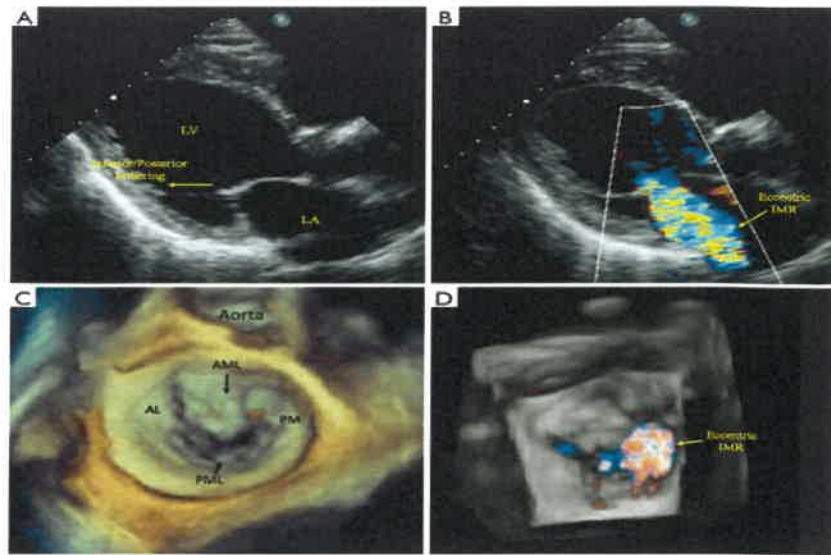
Asymmetric pattern of mitral valve tethering on two- and three-dimensional echocardiography. Asymmetric mitral valve leaflet tethering in the inferior/posterior direction (yellow arrow) results in posteriorly-directed eccentric ischemic mitral regurgitation (IMR) (A,B). En face (surgeon's view) of the mitral valve exemplifies the resultant regurgitant orifice, which is more medially located, and the eccentric MR (C,D). AL, anterolateral commissure; AML, anterior mitral leaflet; IMR, ischemic mitral regurgitation; LA, left atrium; LV, left ventricle; PML, posteromedial commissure; PML, posterior mitral leaflet.
